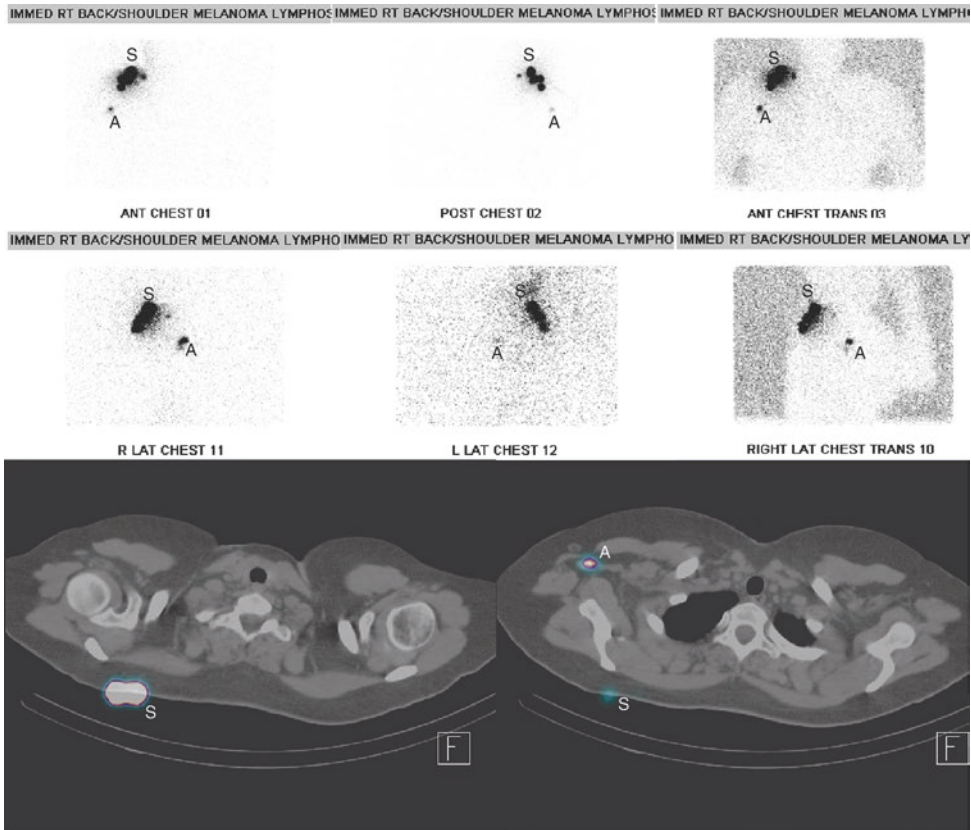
A 36-year-old woman presented with a bleeding nodule on the right upper back. Excisional biopsy revealed a Clarks level IV melanoma, with 6.4-mm Breslow thickness. Wide local excision with sentinel lymph node biopsy was planned. Prior to surgery, lymphoscintigraphy with CT fusion was obtained. *Top row:* Anterior and posterior 2D images of the chest show a large lobulated focus of radiotracer activity at the primary site in the skin (S). Smaller adjacent foci likely represent
